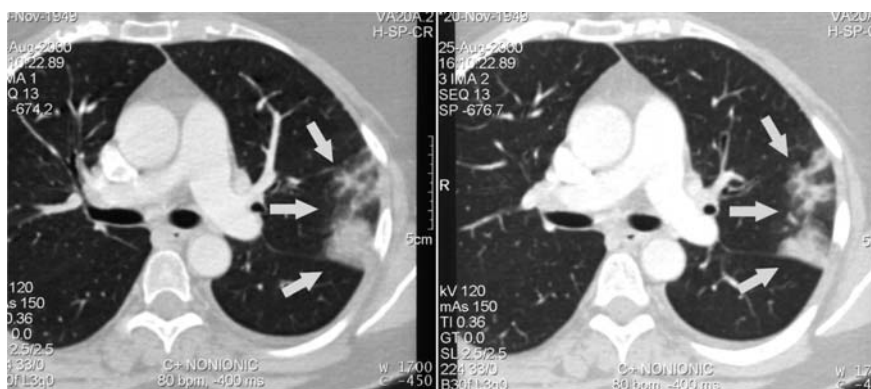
CT scan of a patient with pulmonary consolidation initially attributed to pneumonia. There is a clear lung infiltrate in the periphery of the left lung (arrows). The patient did not respond to several antimicrobial regimens and was subsequently diagnosed with PV stenosis
